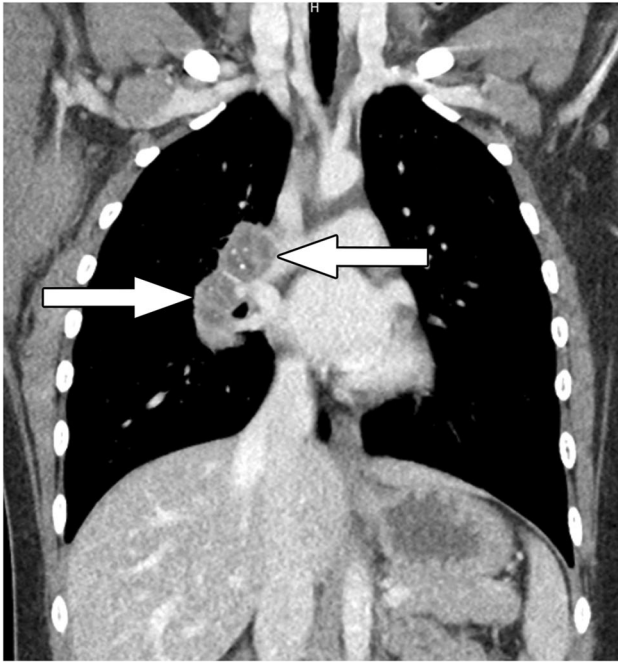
16-year-old girl with active histoplasmosis. Coronal reformat chest CT image with IV contrast material shows enlarged, predominantly hypoenhancing right hilar lymph nodes with septation-like enhancement (arrows) and internal speckled calcifications
